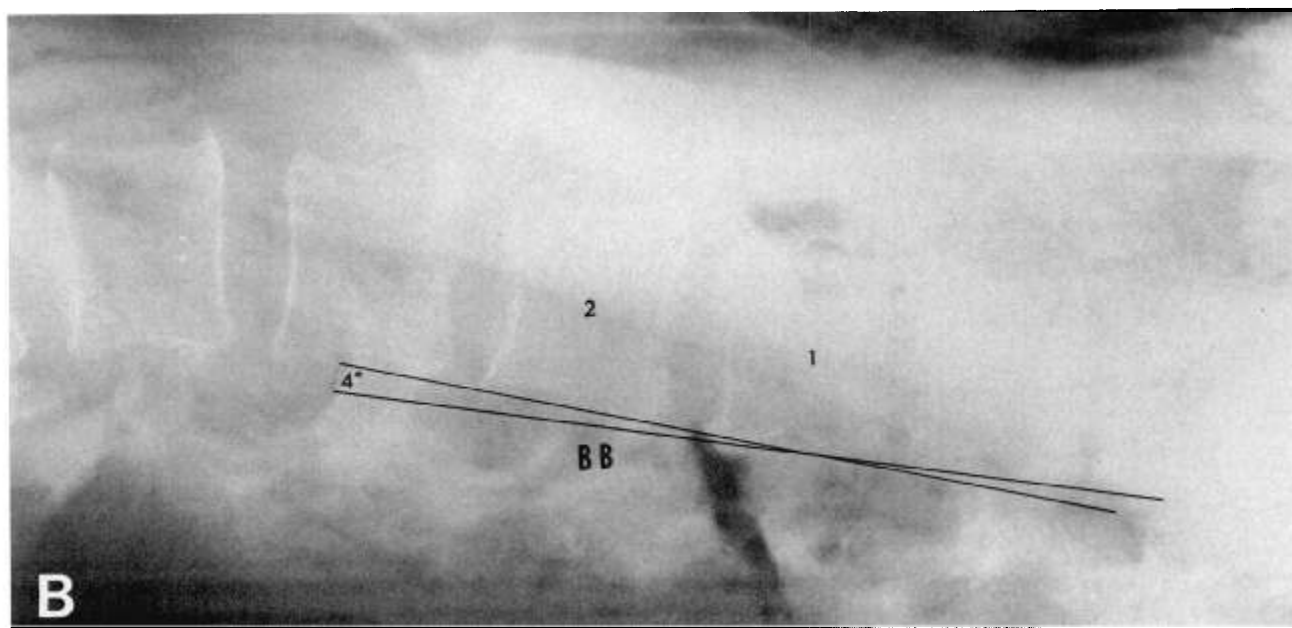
Lateral radiograph of the spine on the backboard reveals the spine to have a 4° angulation at the unstable segment with no anteroposterior displacement.
